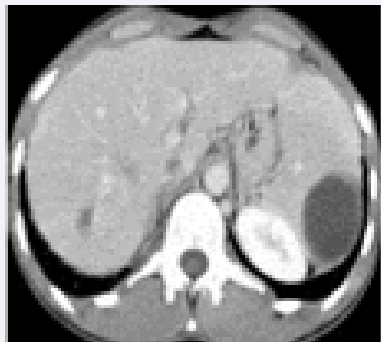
CT scan show cystic lesion of spleen.
